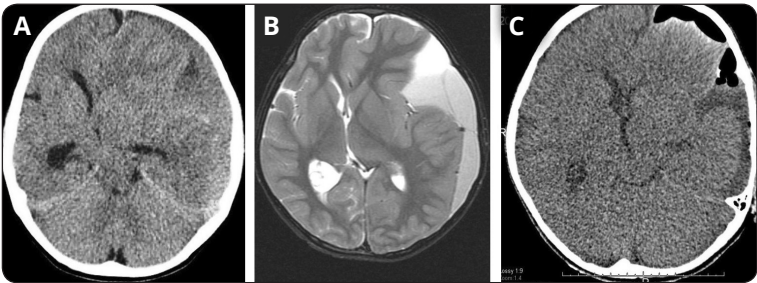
A CT scan shows subdural hemorrhage in the left fronto-temporal region. B MRI shows left chronic subdural hematoma and intracystic hematoma. C Postoperative CT scan shows the vanishing of the subdural and intracystic hematoma
